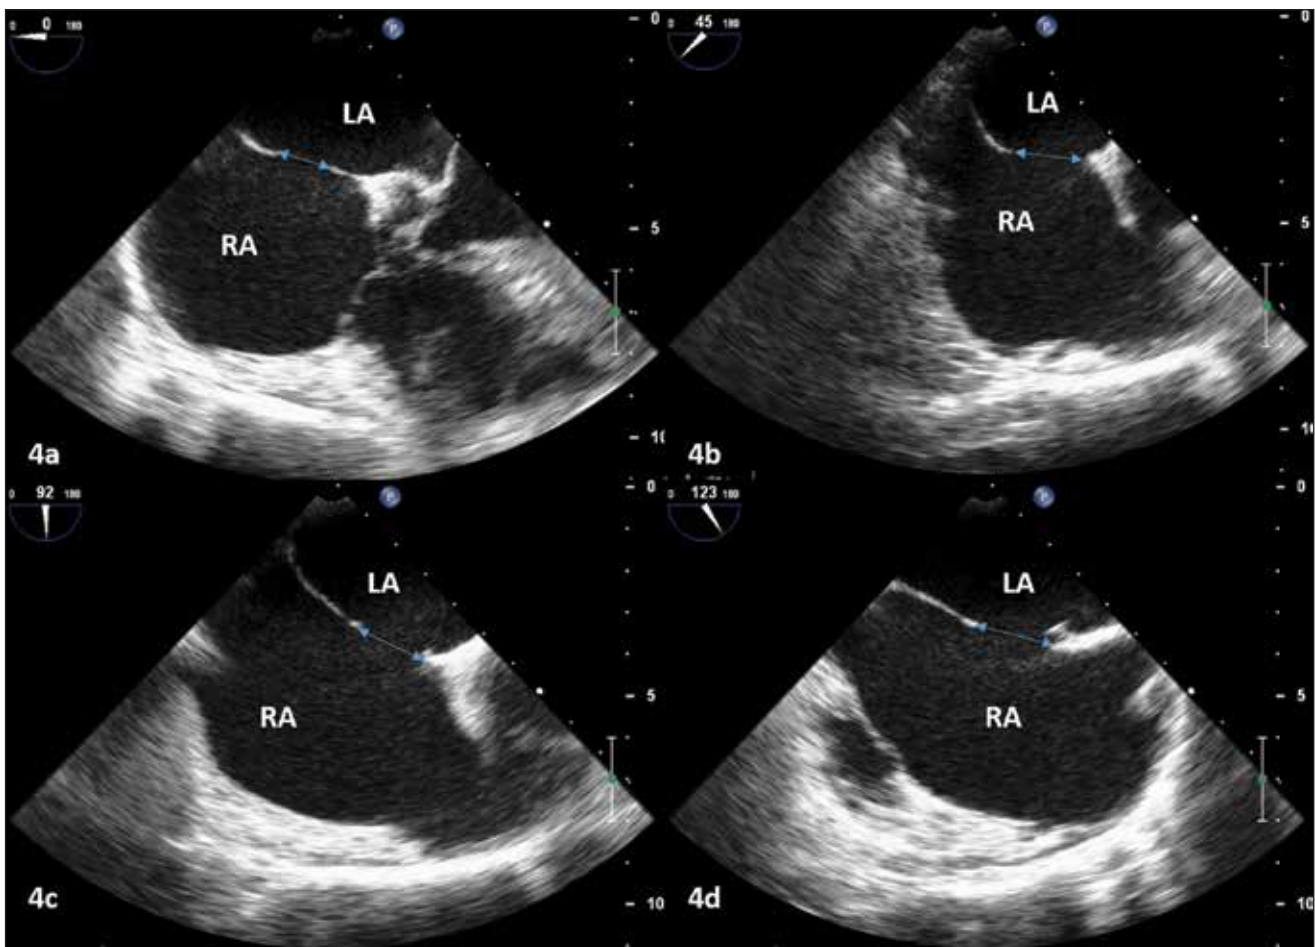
Transesophageal 2D echocardiographic images used in the rapid screening protocol for ASD rims. The 0° mid esophageal projection (panel 4a) shows the mitral rim of the ASD. The aortic rim is identified in the 45° projection (panel 4b). The 90° view (panel 4c) shows the SVC and IVC rims of the ASD. The coronary sinus rim is best visualized in the 120° projection (panel 4d).
